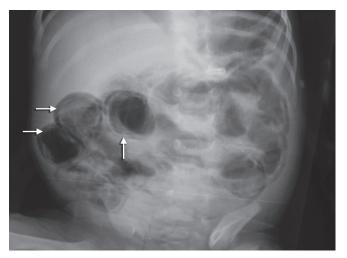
X-ray abdomen showing dilated loops of bowel and intramural gas—*pneumatosis intestinalis* (arrows)
